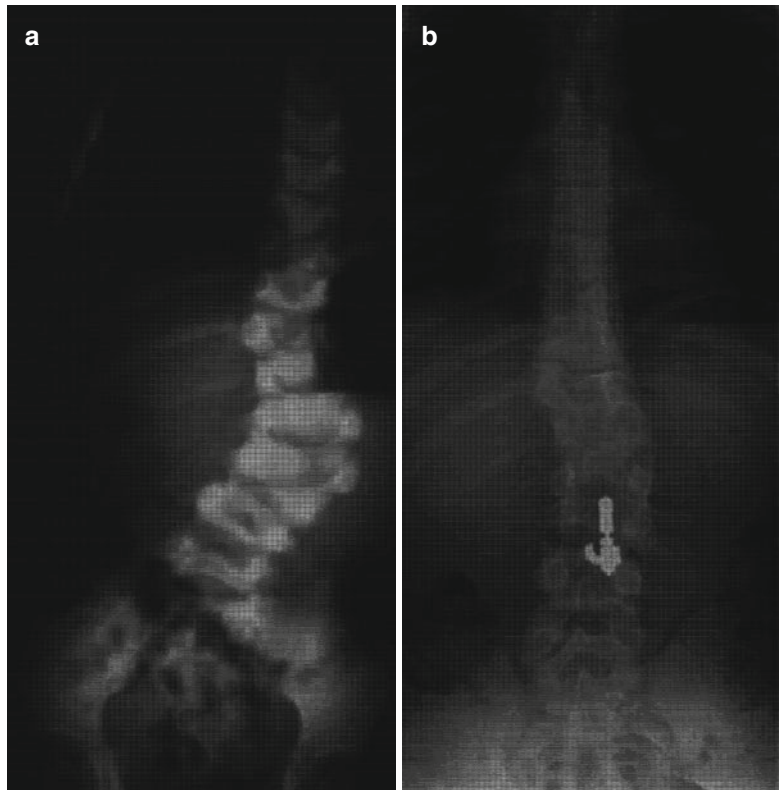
(a) Complex lumbar malformations. Through MRI information a single HV excision was performed. (b) Result at the end of the growth
